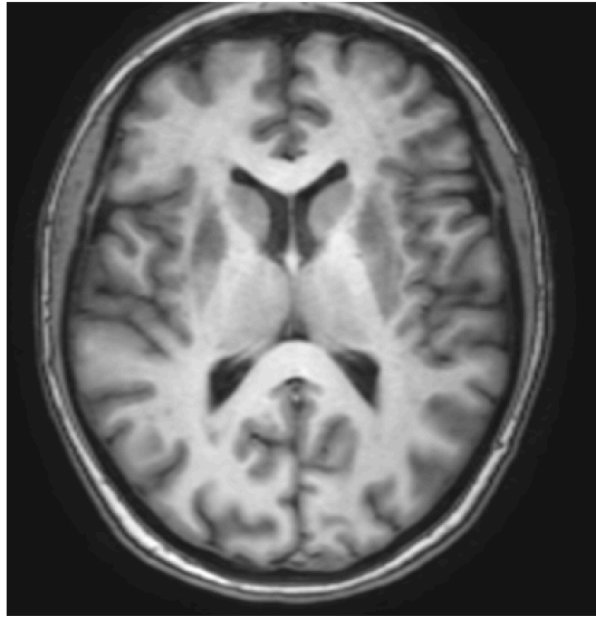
An example of axial T1-weighted MRI image of the human brain.
